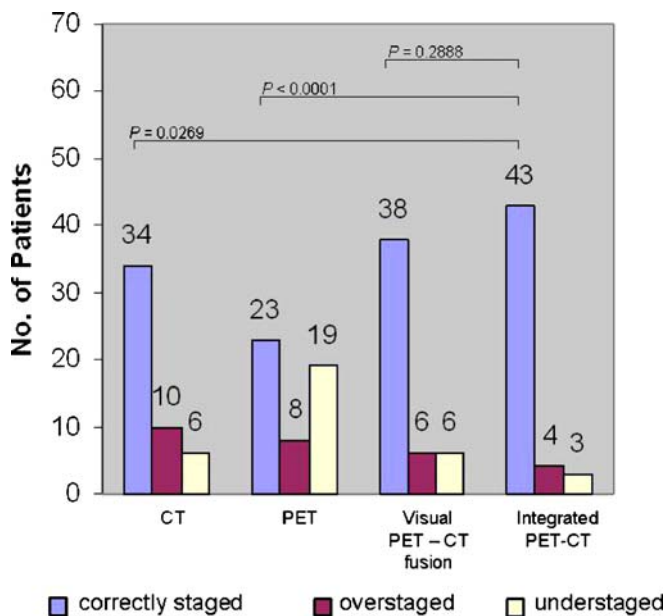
Accuracy of tumor (T) status for integrated PET-CT compared with CT, PET and visually correlated PET-CT
